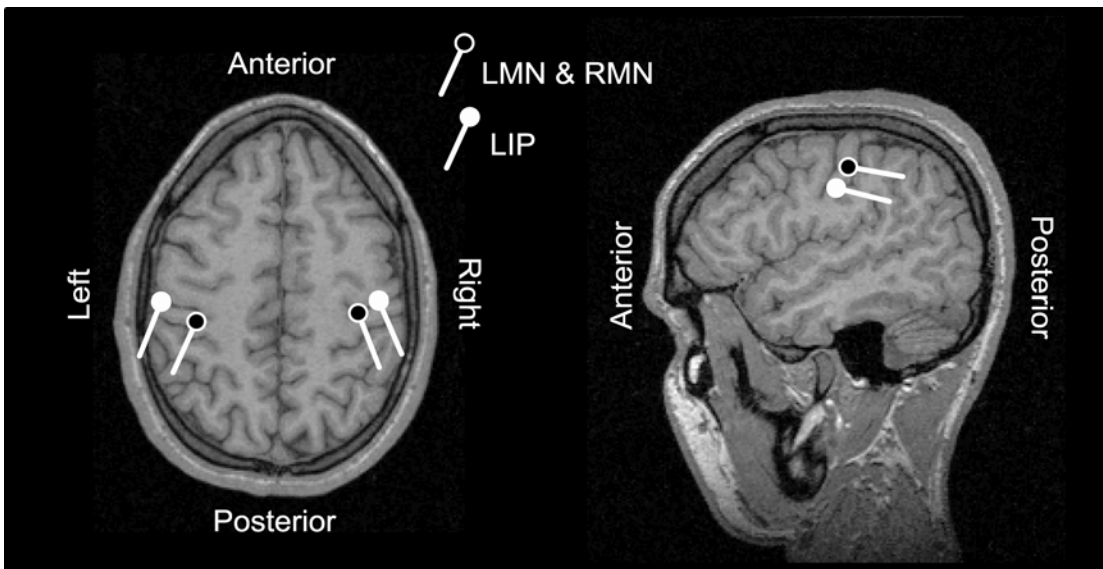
ECDs of Subject 1 to lip and median-nerve stimuli superimposed on the subject's own MR images.
